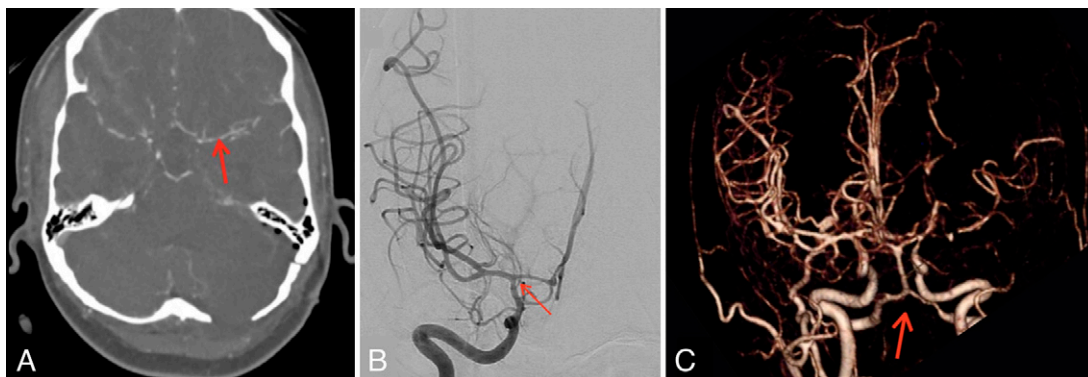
A: Day 6 computed tomography angiogram with focal area of proximal left middle cerebral artery stenosis (red arrow). B: Day 9 digital subtraction angiography showing minor vasospasm of the right carotid (red arrow). C: Day 7 angiographic reconstruction demonstrating mild bilateral intracranial vertebral and basilar artery vasospasm (red arrow).
